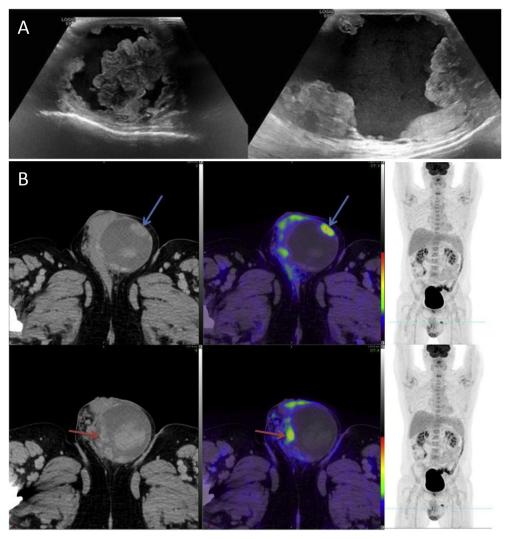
Ultrasonographic and FDG-PET imaging of the scrotal mass.
